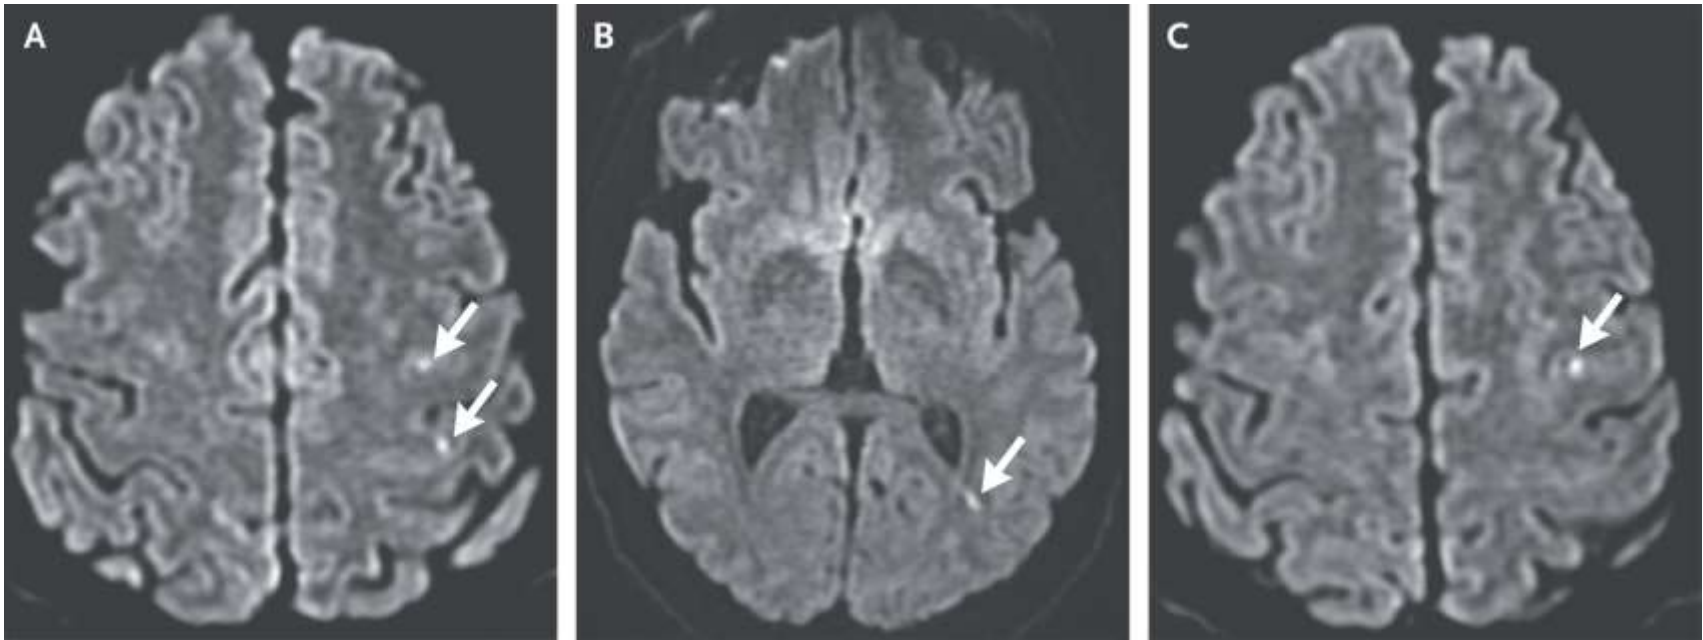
Neuroimaging Evaluation: An axial section of a diffusion-weighted image (MRI) of the brain shows multiple bright spots in the cortical territory of the right middle cerebral artery. Panel A shows two small brain infarctions (arrows), Panel B shows one small infarct (arrow), and Panel C shows one small infarct (arrow).
